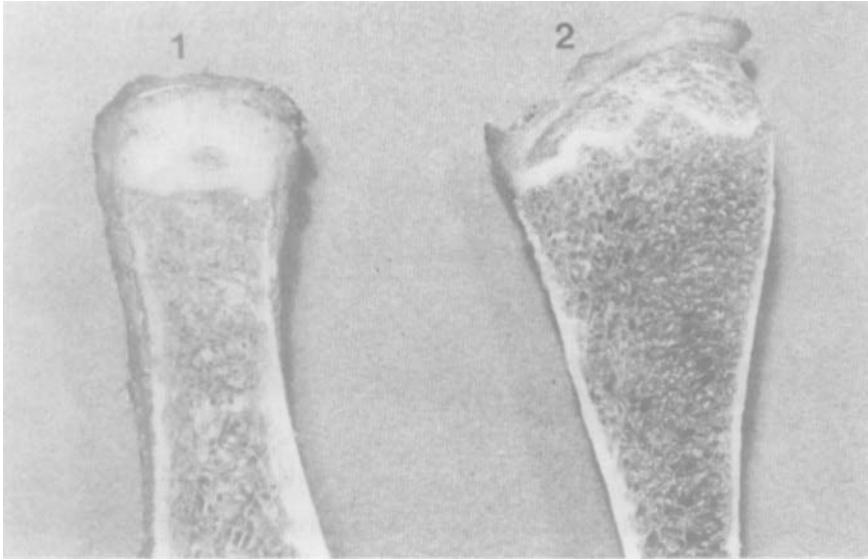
Photographs of vertical sections of iliac crest removed at autopsy from a seventeen year old female patient who died by accident. Section 1 was cut from the anterior part of the iliac crest and section 2 is the posterior part of the same crest. Note in section 1, the cartilaginous iliac crest in which the ossific centre has appeared. This represents a slightly later stage of development than that demonstrated in the previous radiographs (Fig. 46).
